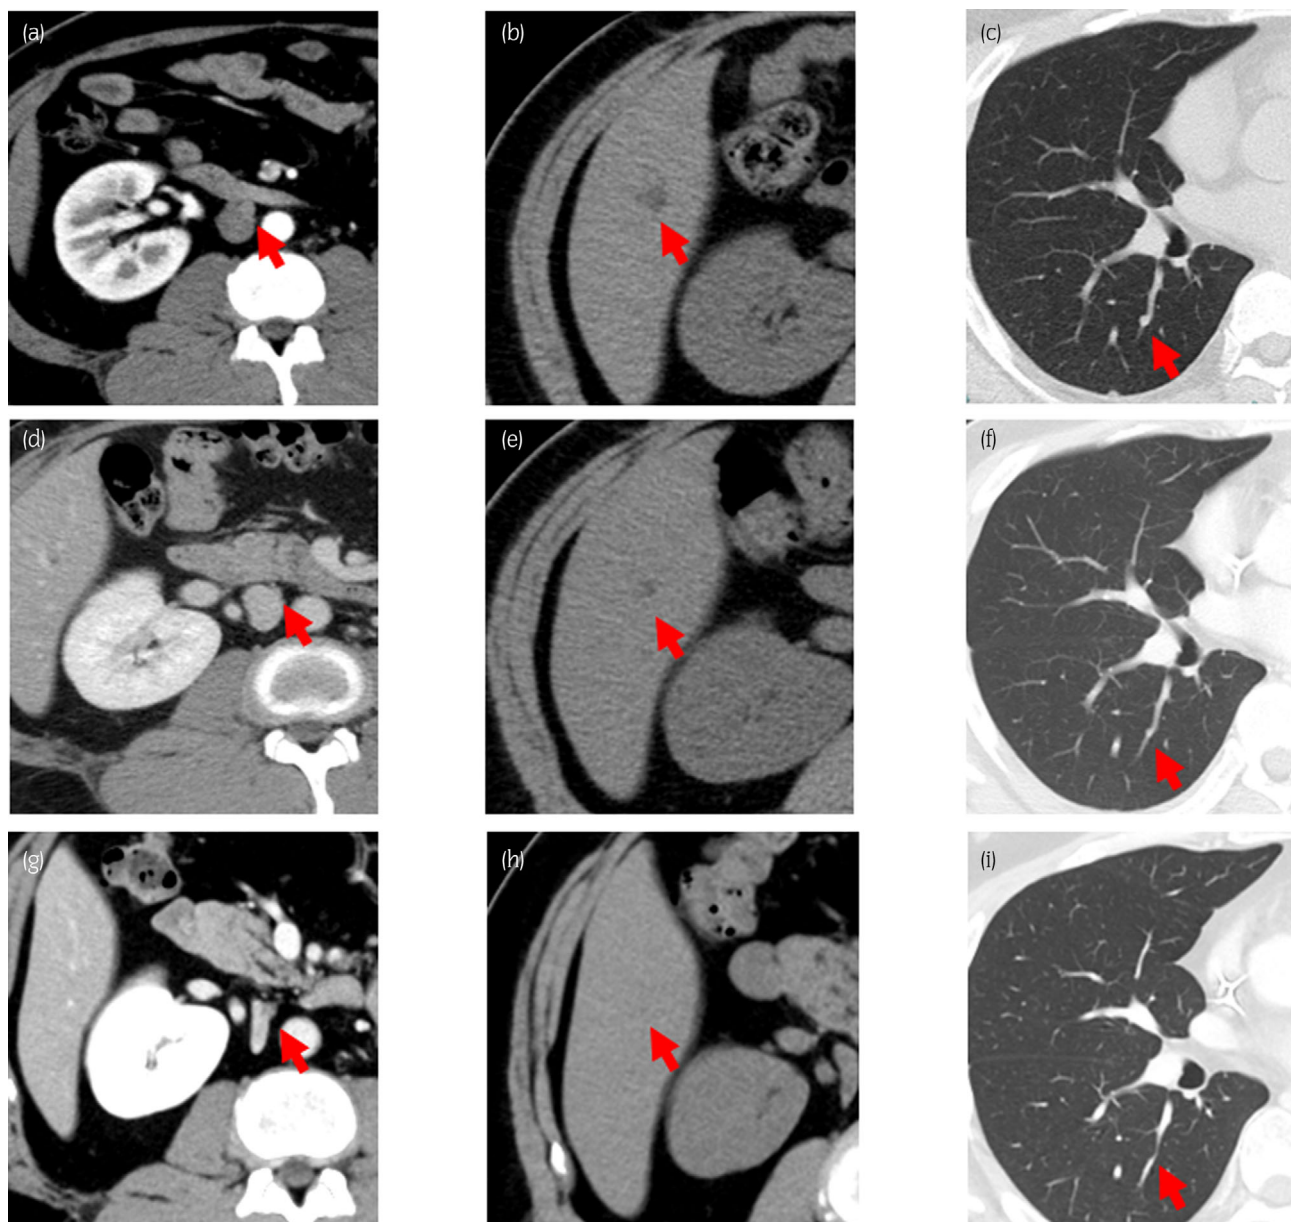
Before EDP-M (a–c), after four cycles of EDP-M (d–f), and after 15 months of PEM-M (g–i). Axial image of abdominal and chest CT indicating a 10 mm mass of the inferior vena cava (a), a 13 mm mass at segment six of the liver (b), and a 6 mm mass at segment six of the lung (c) before EDP-M. Axial image of abdominal and chest CT indicating a 4 mm mass of the inferior vena cava (d), a 7 mm mass at segment six of the liver (e), and a 4 mm mass at segment six of the lung (f) after four cycles of EDP-M, which were in a stable disease state. Axial image of abdominal and chest CT indicating a 7 mm mass of the inferior vena cava (g), disappearance of the mass of segment six of the liver (h), and disappearance of the mass of segment six of the lung (i) after 15 months of PEM-M, indicating a partial response.
